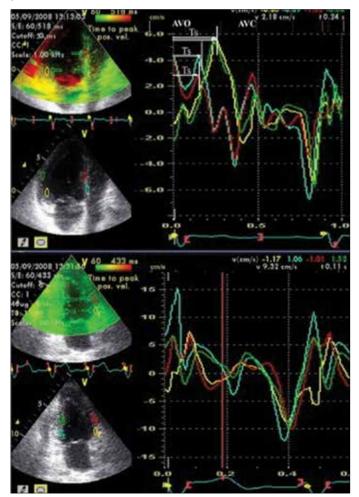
Graphic showing the duration to peak systol and apical four cavity and two cavity TSI images of a patient with acute MI
